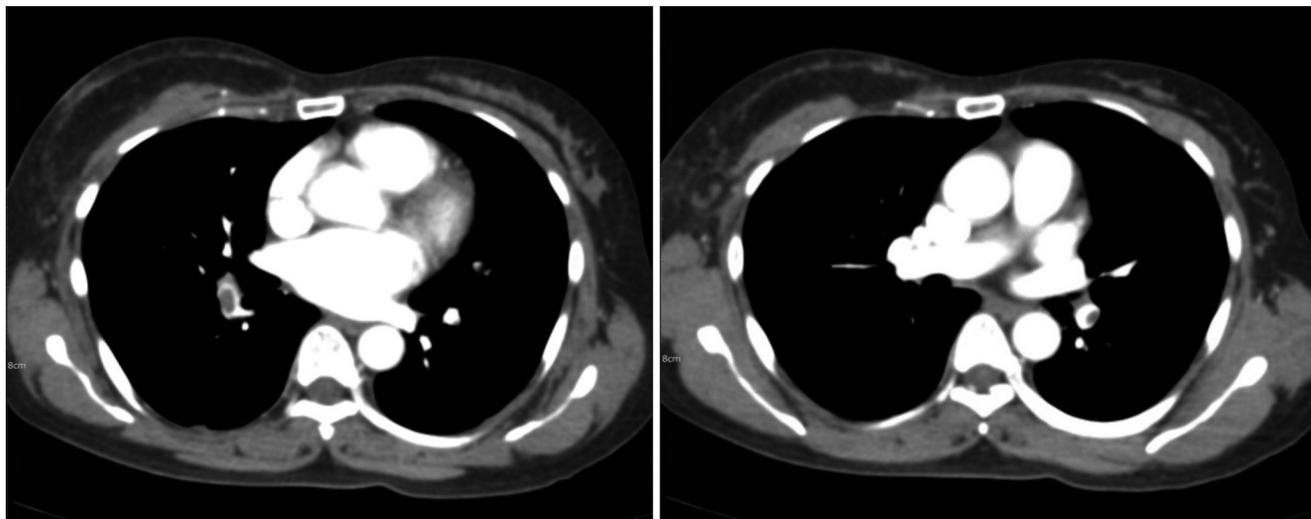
Chest computed tomography angiography with pulmonary artery embolism on both lobes.
